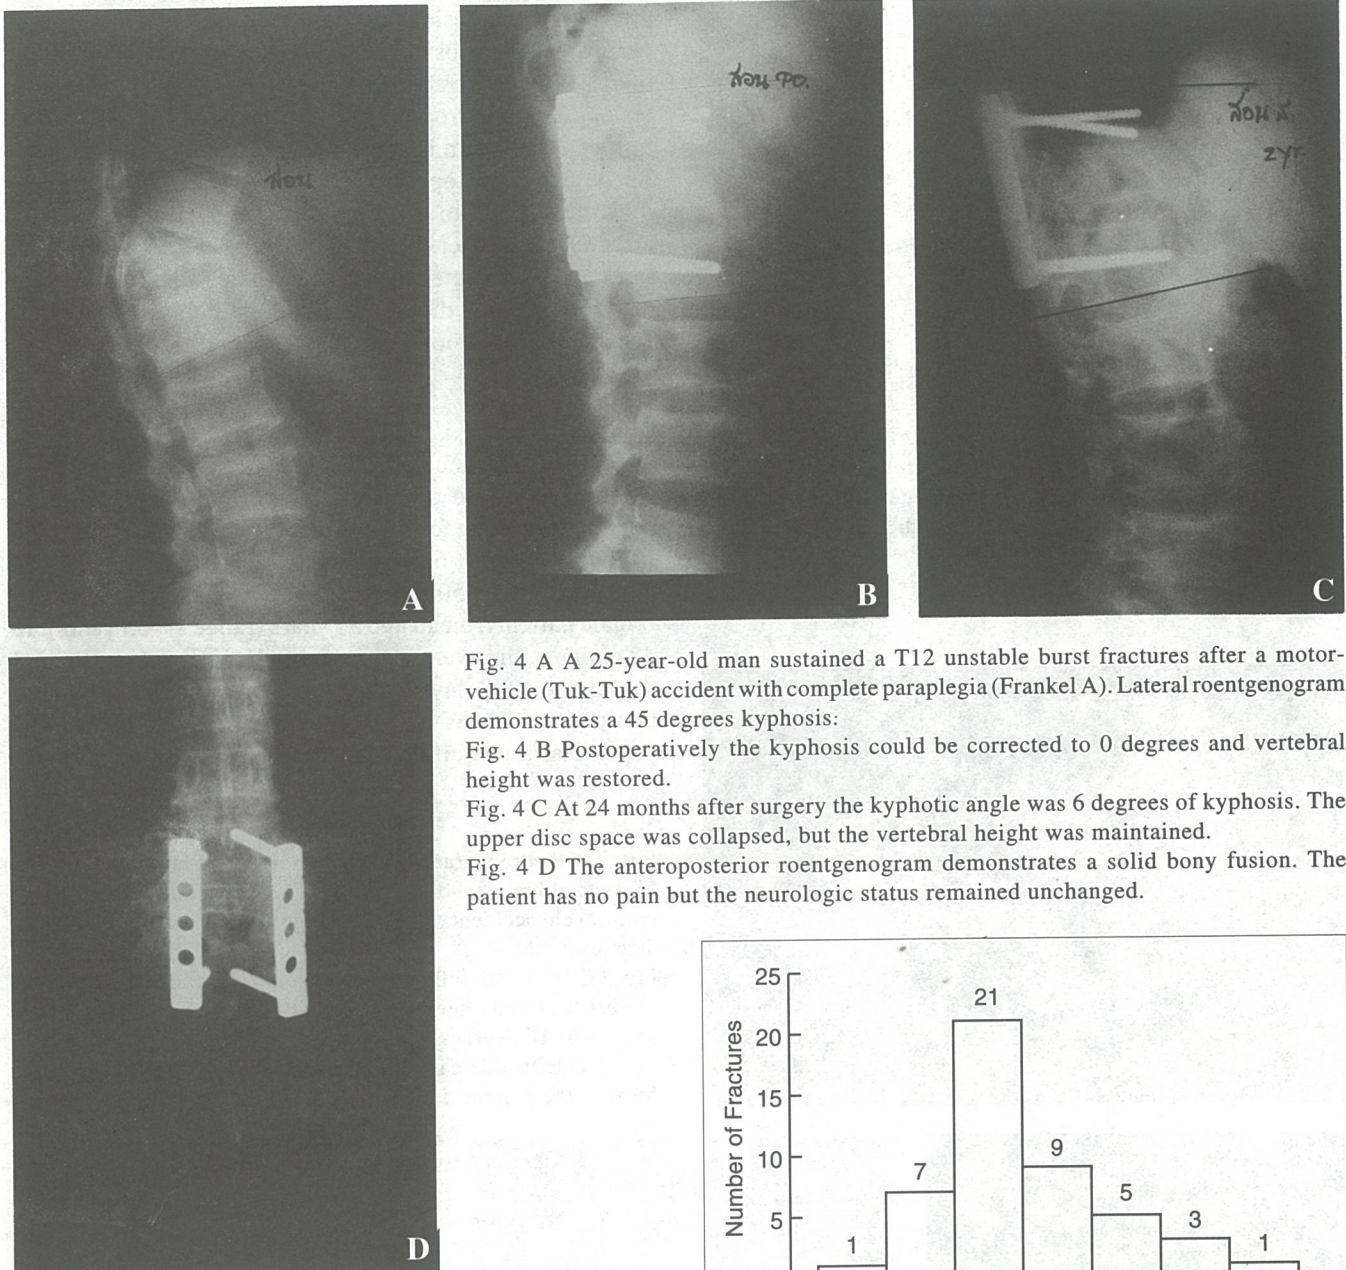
A A 25-year-old man sustained a T12 unstable burst fractures after a motor-vehicle (Tuk-Tuk) accident with complete paraplegia (Frankel A). Lateral roentgenogram demonstrates a 45 degrees kyphosis:
